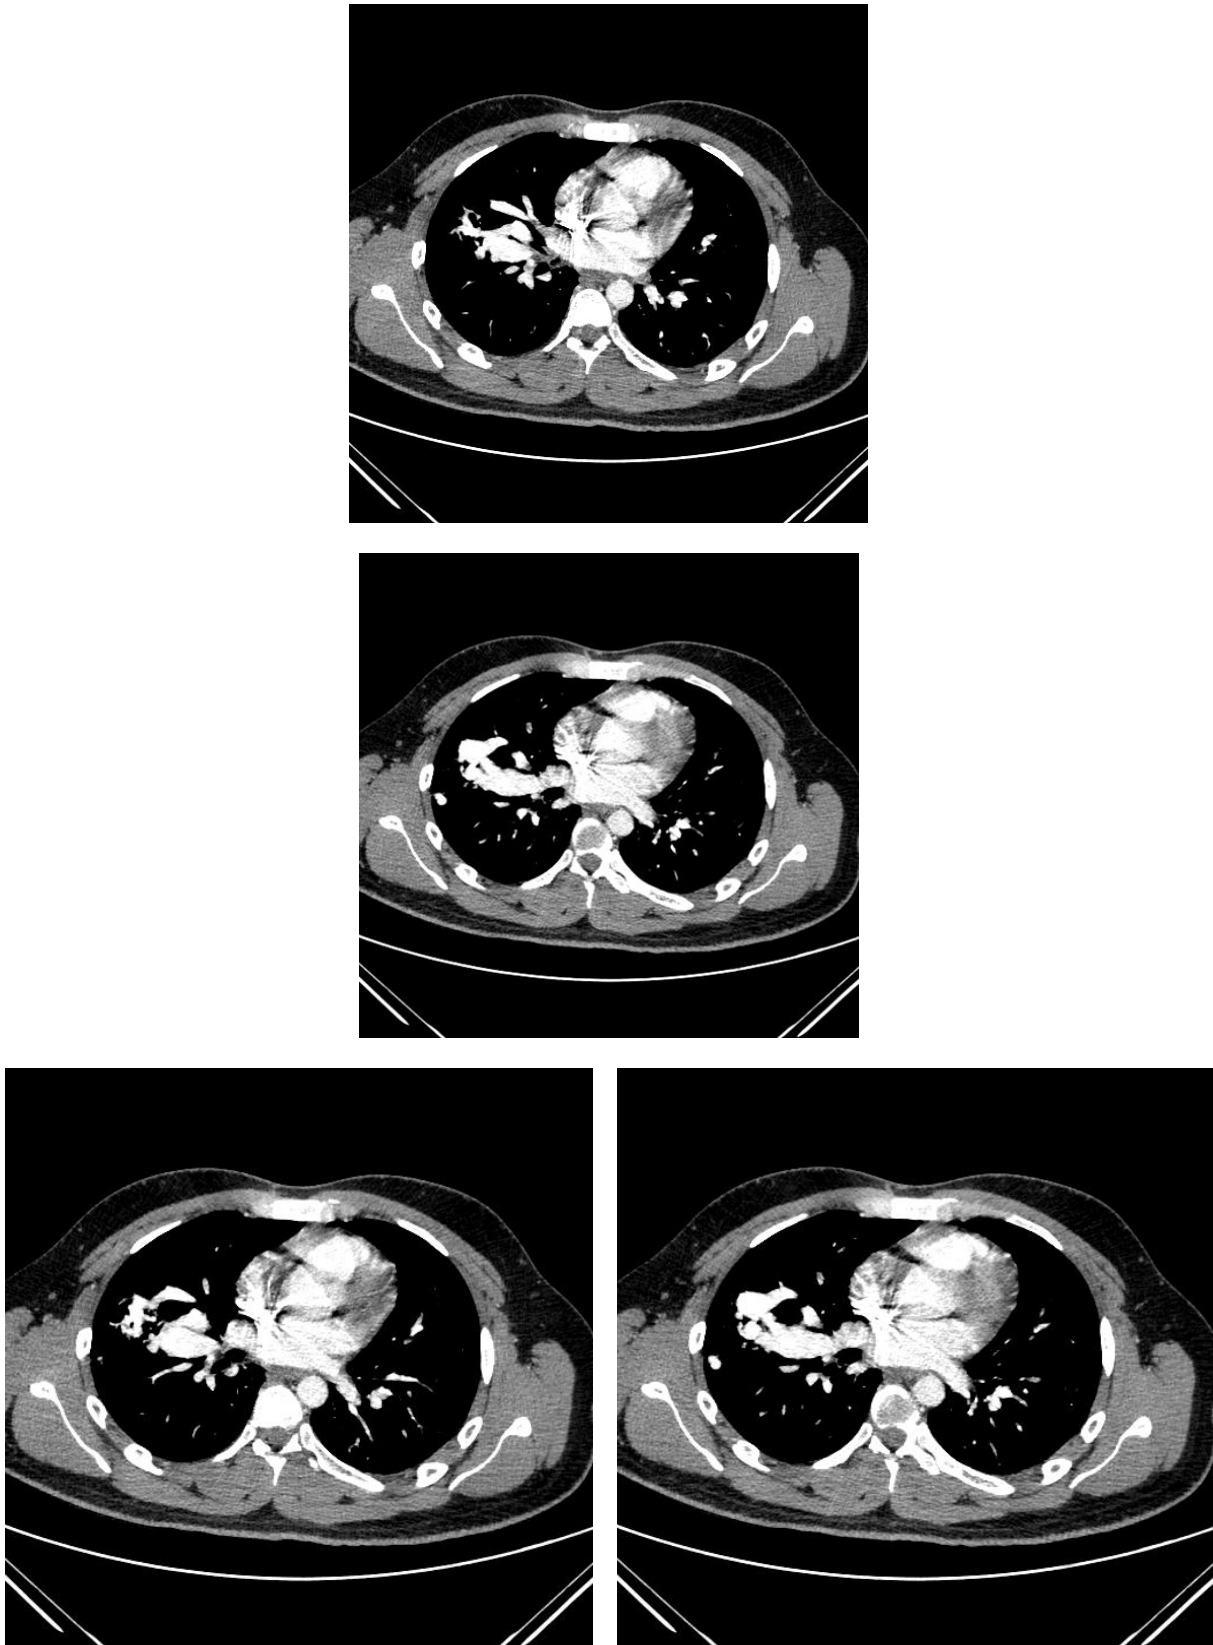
Axial contrast enhanced CT scans of the same patient revealed multiple sependeous contrast filled pulmonary AV fistulae, largest in the right middle lobe measuring approximately 6 x 3.5 cm, supplied by multiple dilated arteries from the lateral segment with a large dilated vein draining into the superior pulmonary vein just before the insertion into the left atrium.
